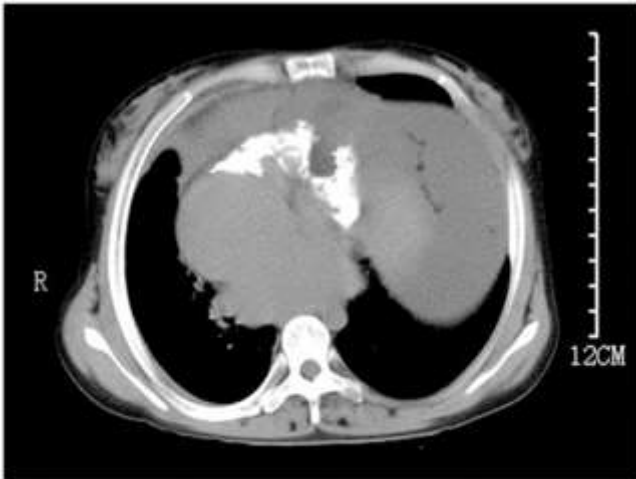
An axial view of chest computed tomography showing the severely calcified pericardium over the right heart.
